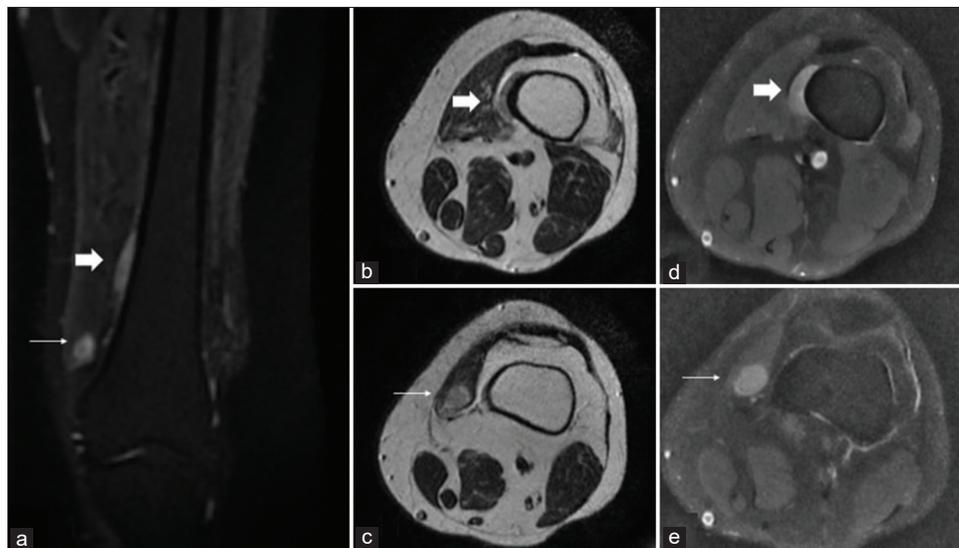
MRI revealed, two lesions hyperintense on Coronal STIR image (a). Lesion in intramuscular location is hyperintense on T2 axial image (thin arrow in c) and showed homogenous enhancement (thin arrow in e). Another similar intensity lesion based on periosteum of left femur (thick arrow in a, b, d)
